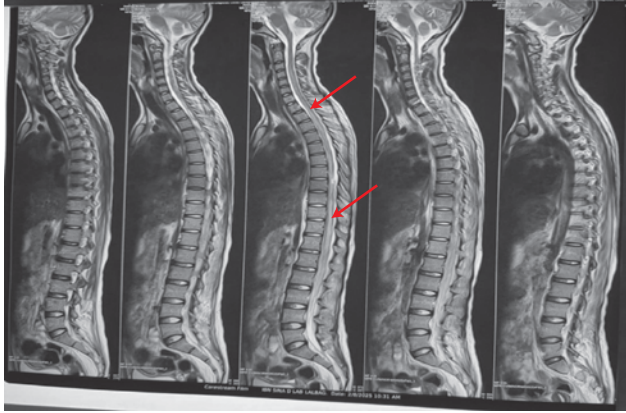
MRI of Spine with contrast shows T2 hyperintensity (red arrow) in the spinal cord from C3-D12 level
